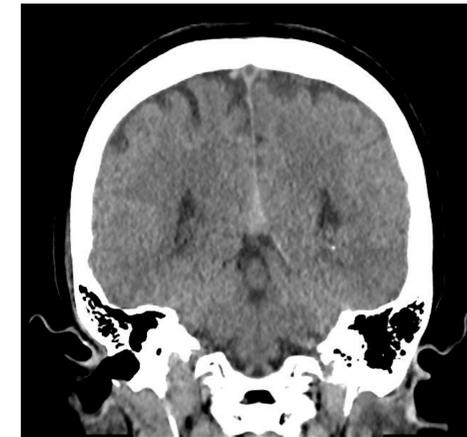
Computed tomography with venography of the head demonstrating empty delta sign
